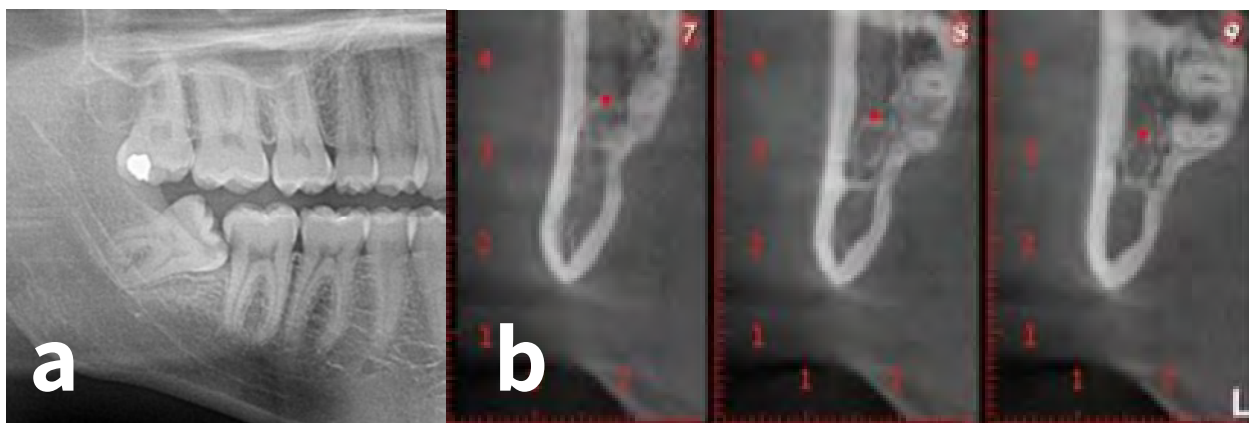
Panoramic radiography indicating proximity between right and left mandibular third molar and the IAN.
